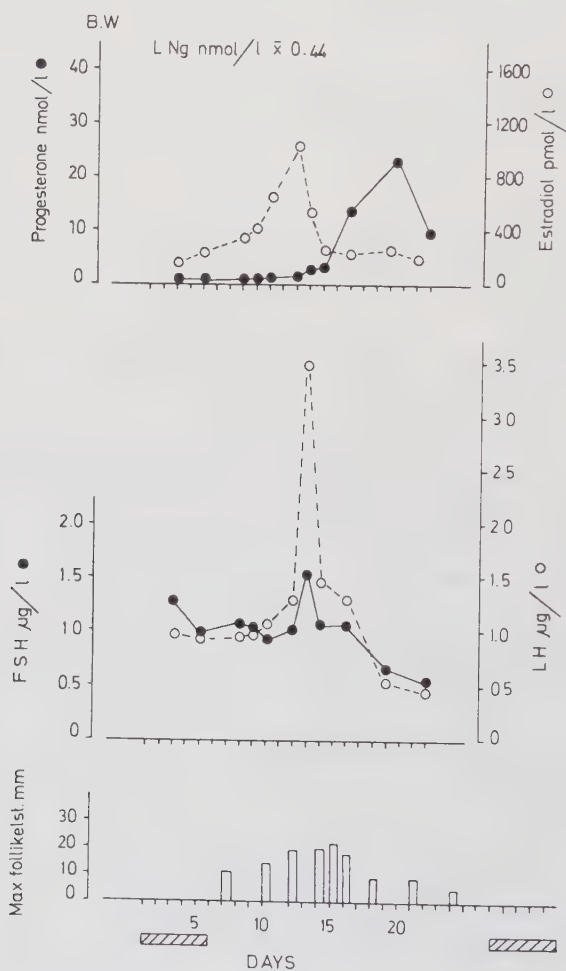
Plasma concentrations of estradiol, progesterone, FSH and LH during a menstrual cycle in one woman who had used NORPLANT-2 implants for more than three years. Ultrasound determinations of follicle diameter shows a normal follicular development and rupture. Days are numbered from the first day of menstrual bleeding.
